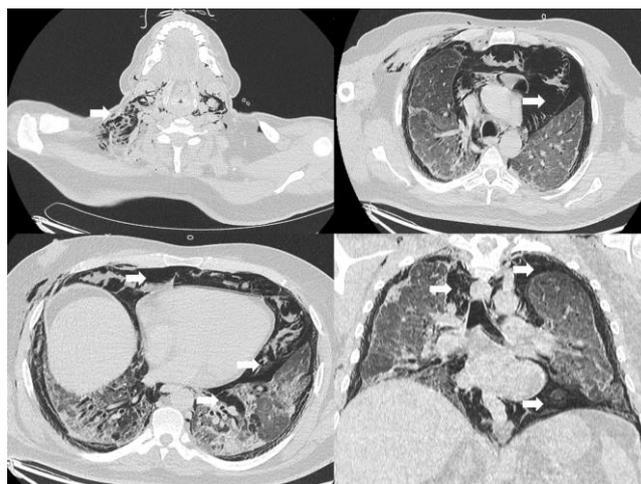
Chest CT scan showing extensive subcutaneous emphysema in the neck, bilateral extensive pneumothorax and pneumomediastinum. Bilateral pulmonary emphysema seen in the lower lobes (arrows)
